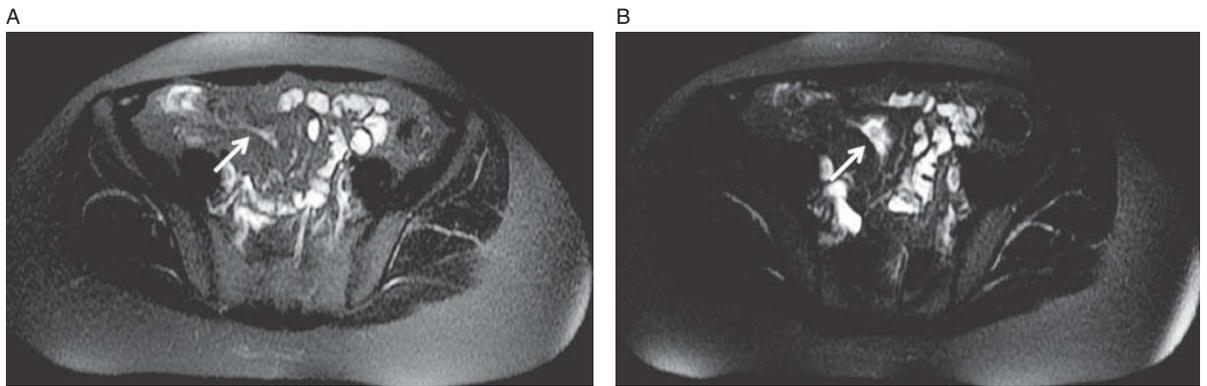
Chronic stricture. Axial T2-weighted image (A) demonstrates marked narrowing of the terminal ileum which persisted on all sequences. Note the lack of elevated T2 signal. Axial T2-weighted image (B) shows prestenotic dilatation which confirms presence of stricture.
